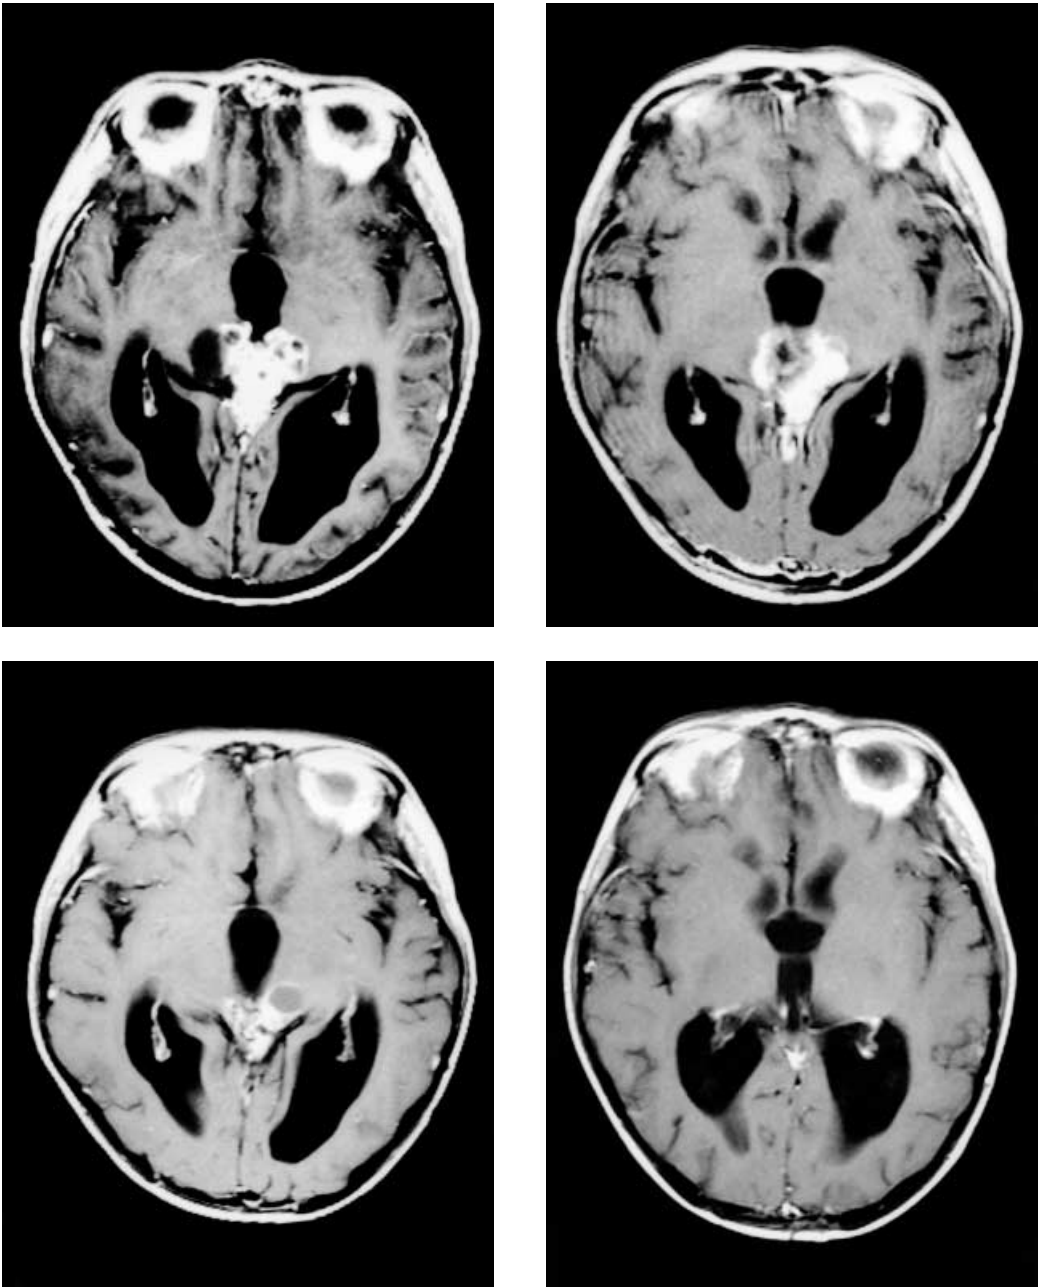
T1-weighted transverse postcontrast MRIs of the patient.
